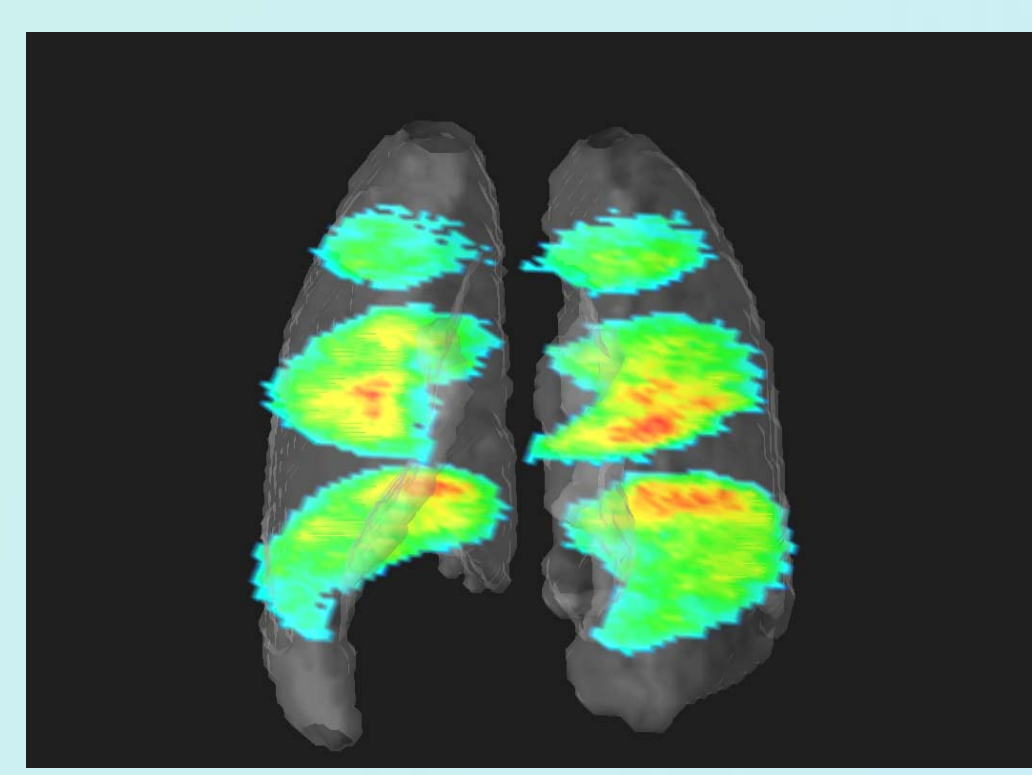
The MRI-based lung model and the corresponding SPECT data for a single slice.
